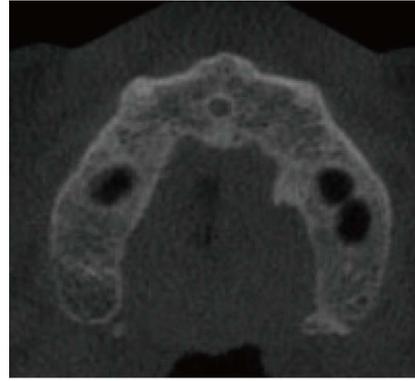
Axial view from cone beam computed tomography with septum on left maxillary sinus.
